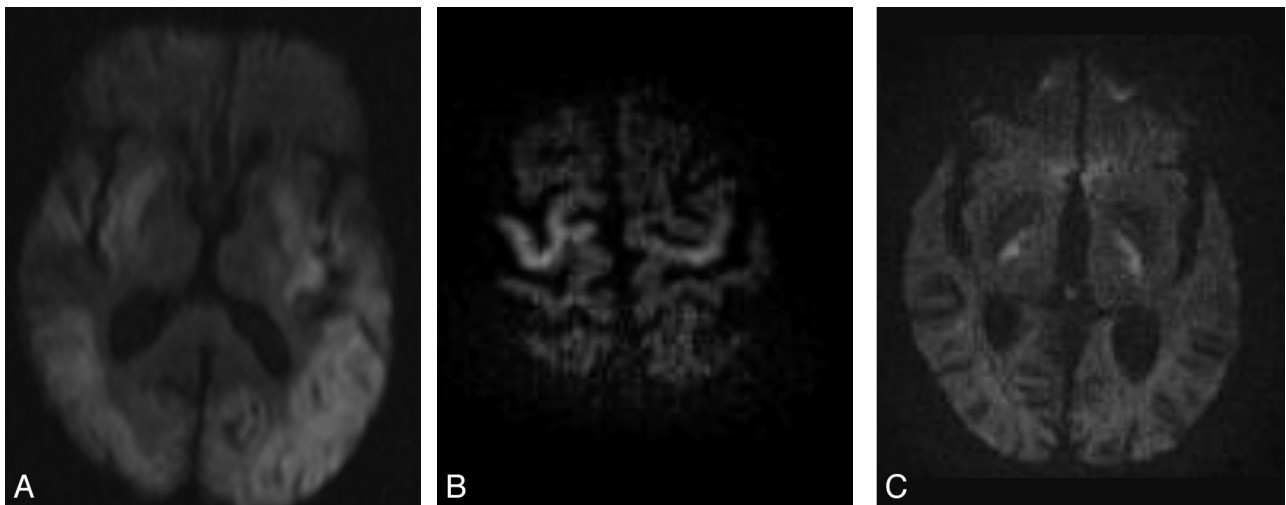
DWI studies in patients with HE show abnormal signals at the bilateral temporo-occipital lobes, patient 1 (A); bilateral precentral gyrus, patient 2 (B); and bilateral internal capsules, patient 3 (C).
